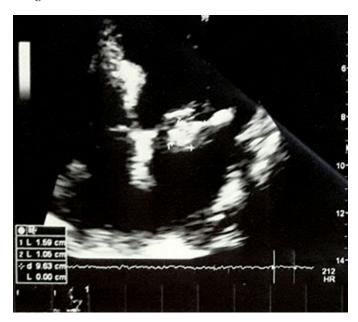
Thoracic echocardiography showing a mitral valve with echoic image suggestive of endocardial vegetation.
